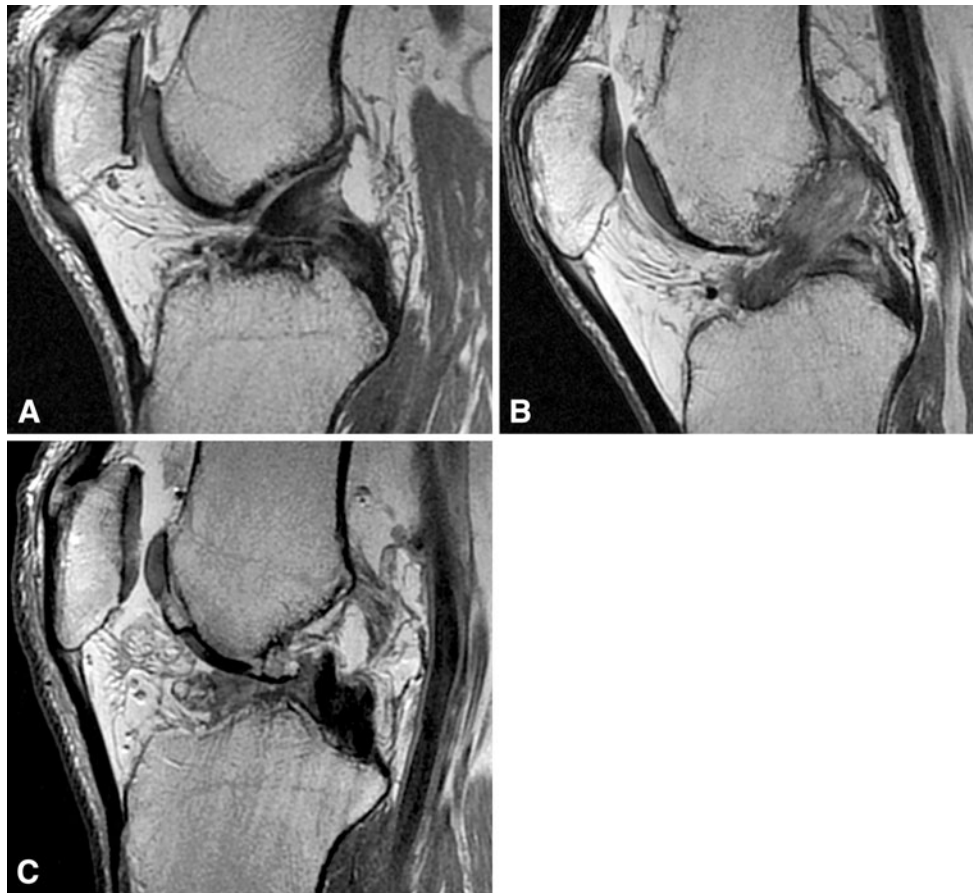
Sagittal T1-weighted MR images demonstrating the grading system for ACL integrity before TKA. The ACL was graded as intact (A) when there was normal ACL volume, the ACL had a normal course from the tibia to femur, and there was consistently low signal intensity through its entire length. The ACL was graded as indeterminate (B) if there was normal volume and course but
